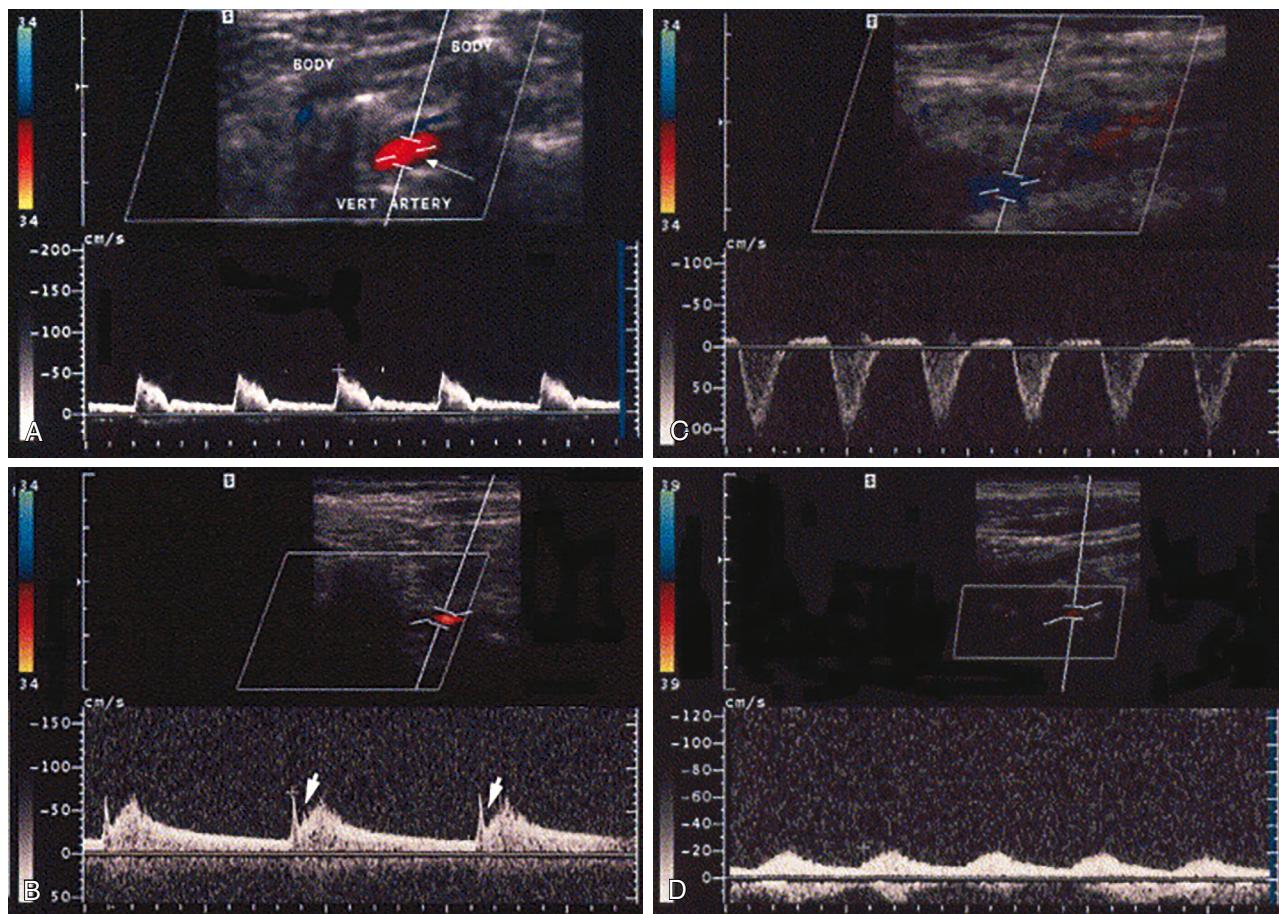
Doppler waveforms typical of subclavian artery stenosis. (A) Normal antegrade vertebral waveform. (B) Latent subclavian steal demonstrating a presteal or "bunny" waveform characterized by an early to midsystolic dip in the Doppler waveform. (C) Retrograde systolic flow in the vertebral artery seen in hemodynamically significant subclavian stenosis. (D) Dampened Doppler waveform indicative of proximal obstruction within the ultrasounded artery. (Adapted from Kalaria VG, Jacob S, Irwin W, et al. Duplex ultrasonography of vertebral and subclavian arteries. J Am Soc Echocardiogr. 2005;18(10):1107-1111.)
